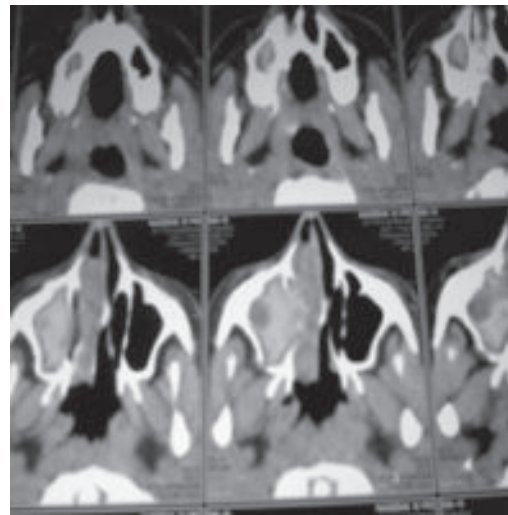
CT scan of nose, nasopharynx, paranasal sinuses and skull base axial and coronal views showing heterogeneous mass involving right nasal cavity, right maxillary and ethmoid sinuses with double density sign characteristic of fungal infection.
